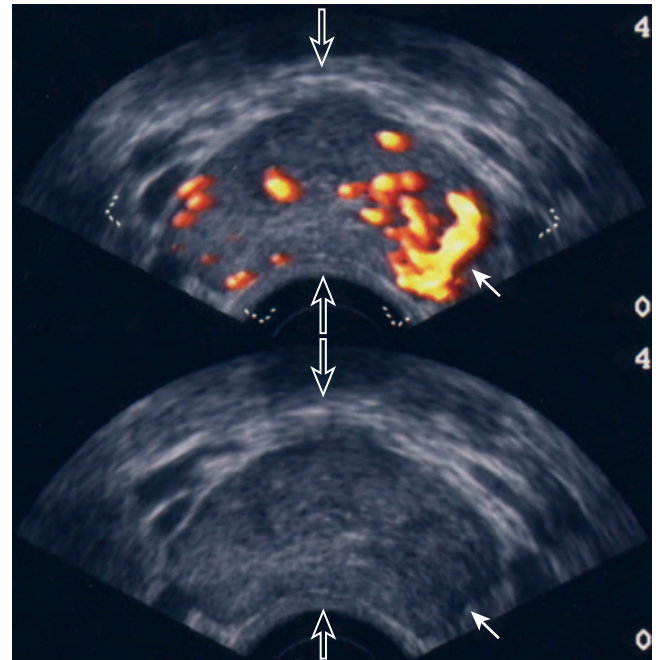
Transrectal ultrasound examination demonstrates increased flow on color Doppler study at the left posterior (*upper panel, arrow*) with corresponding hypoechoic area on gray-scale images (*lower panel, arrow*). Note the left lateral distortion and squaring of the capsule, suggesting extracapsular extension. (Courtesy Dr. Katsuto Shinohara.)
